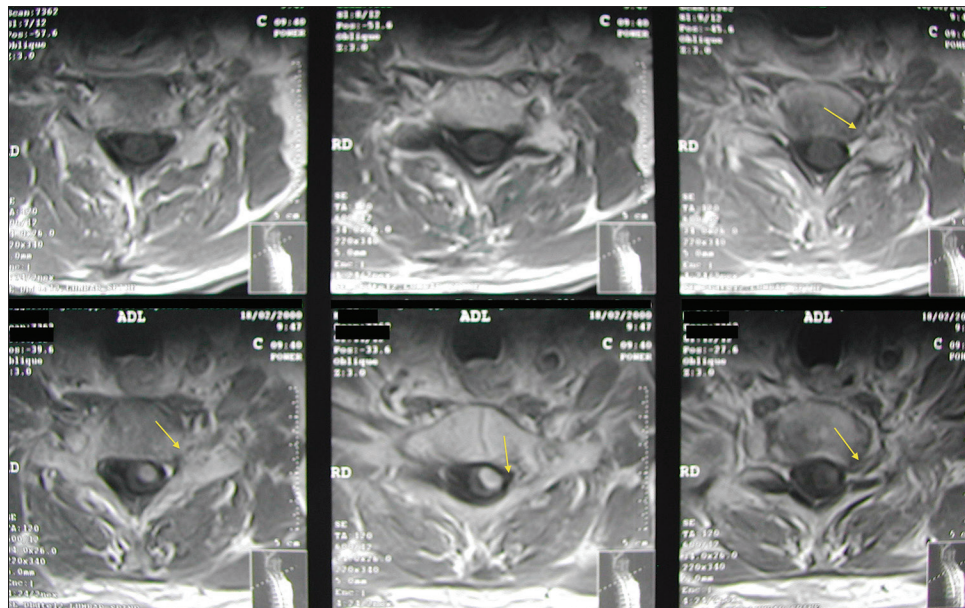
Axial T1-weighted magnetic resonance images after gadolinium injection, showing intradural enhancing mass, with no evidence of transdural extension or foramina involvement (yellow arrows)
